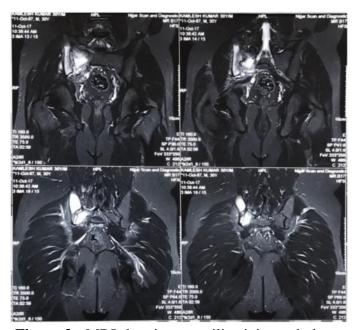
MRI showing sacroiliac joint pathology
